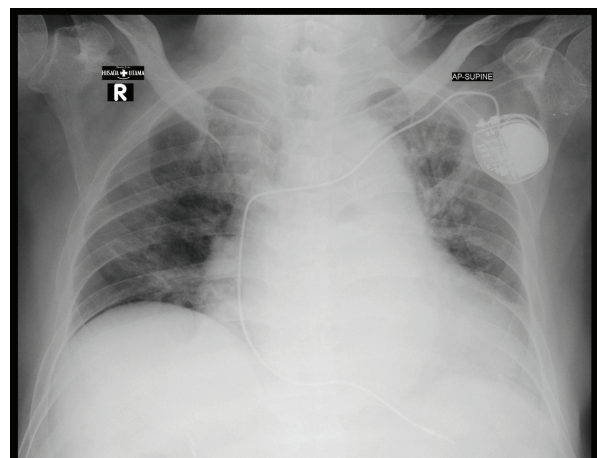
Pneumonia COVID-19 chest x-ray.
